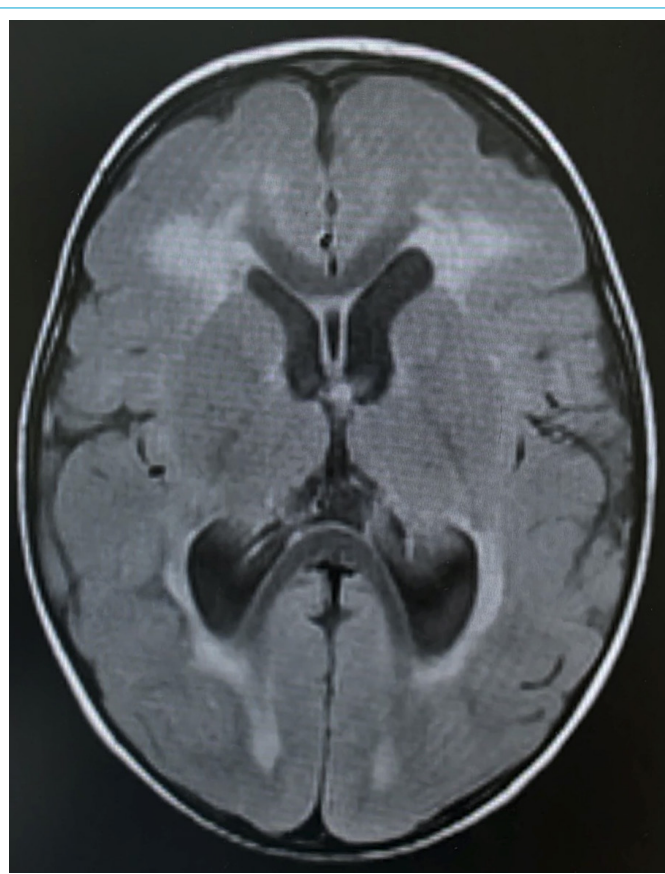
Axial T2-FLAIR brain MRI of a patient with classic PKU, demonstrating bilateral symmetric hyperintensities in the periventricular white matter, consistent with gliotic changes. The lateral ventricles appear enlarged, secondary to atrophy.
